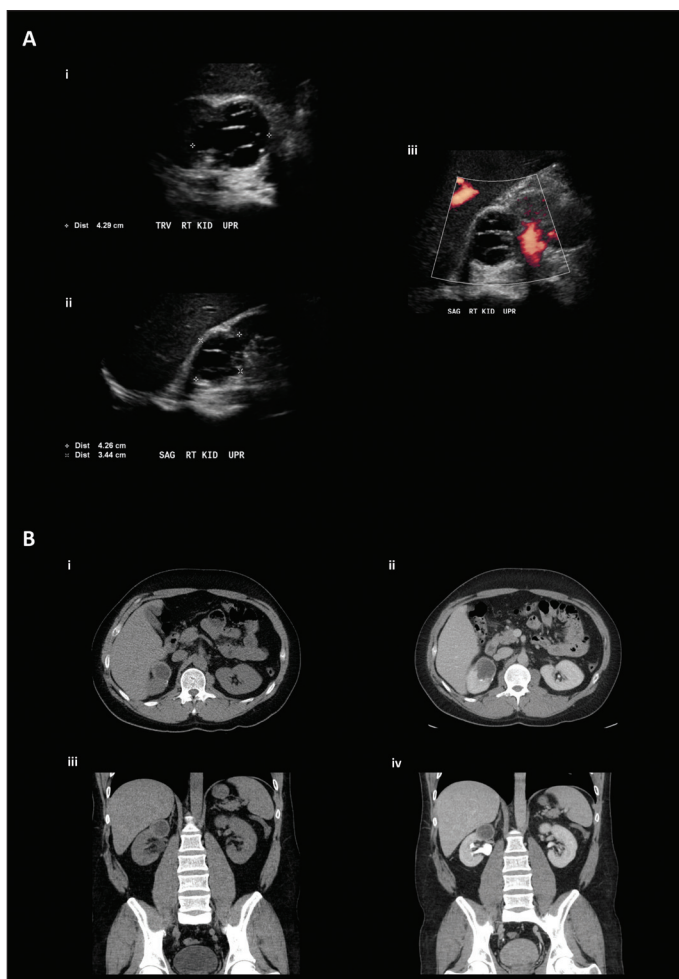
(A) Ultrasound images of complex right renal cyst: (i) transverse view; (ii) sagittal view; (iii) sagittal view with doppler flow. (B) Triphasic computed tomography images of complex right renal cyst: (i) selected non-contrast axial image; (ii) selected arterial and urogram phase axial image; (iii) selected non-contrast coronal image; (iv) selected arterial and urogram phase coronal image.
